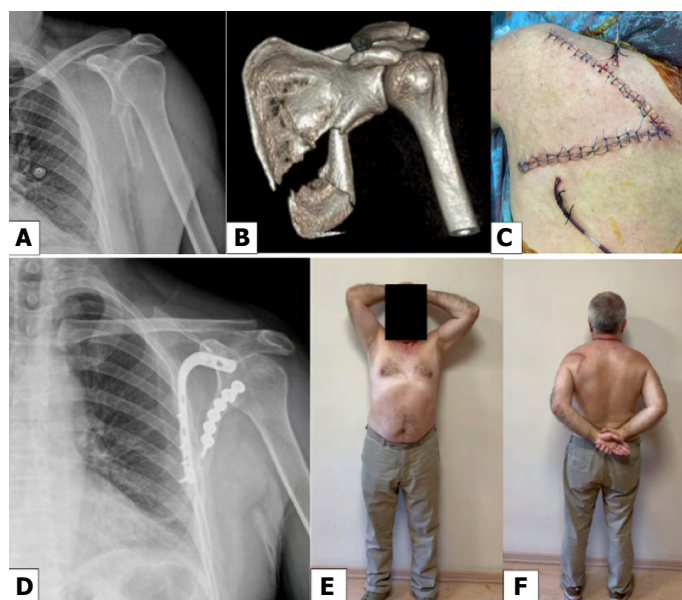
Representative case of a complex displaced scapular fracture treated with open reduction and internal fixation using the modified Judet approach. (A) Pre-operative radiograph demonstrating fracture displacement. (B) Three-dimensional computed tomography reconstruction showing fracture configuration and involvement of the scapular body. (C) Intraoperative photograph demonstrating the modified Judet approach and surgical exposure. (D) Post-operative radiograph showing anatomical reduction and stable fixation. (E) Clinical photograph demonstrating satisfactory forward elevation. (F) Clinical photograph demonstrating internal rotation at final follow-up.
